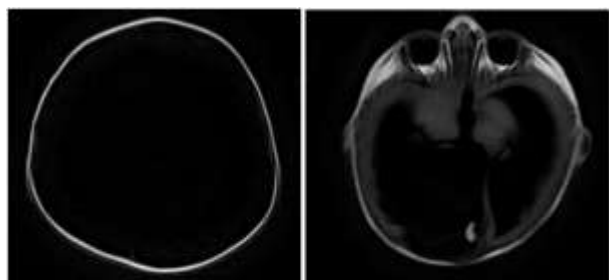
T1W MRI axial section shows supra tentorial cerebral parenchyma replaced by CSF density
